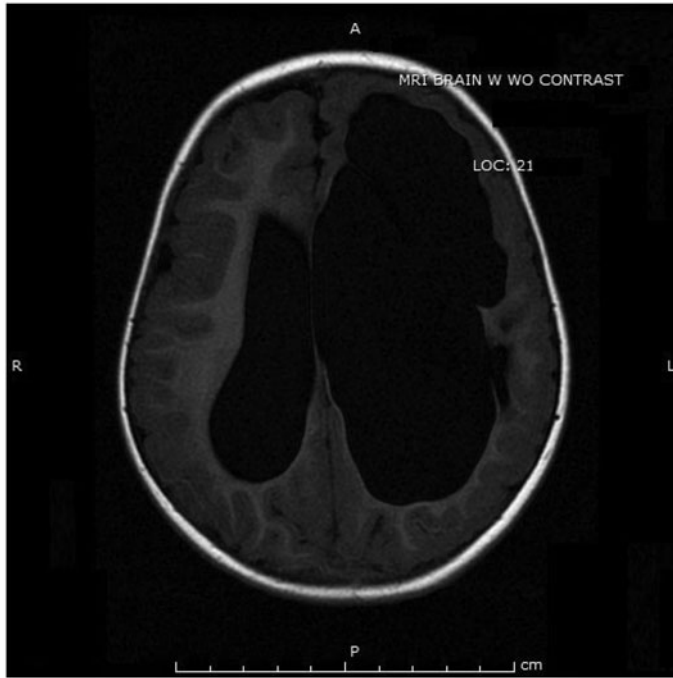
Brain magnetic resonance imaging at 1 year of age revealing severe bilateral volume loss.
